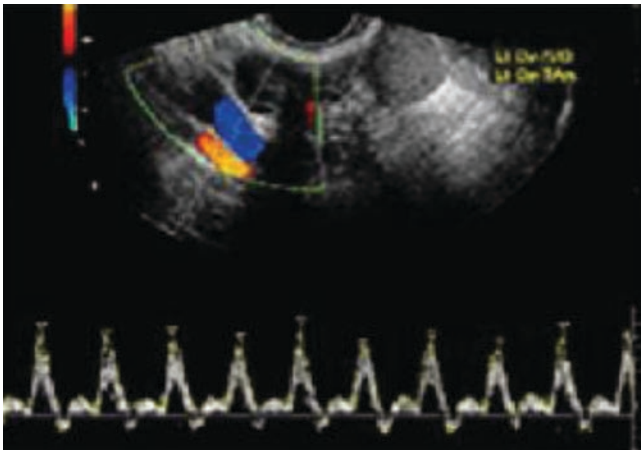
Color Doppler flow image and spectrum of the internal iliac artery
